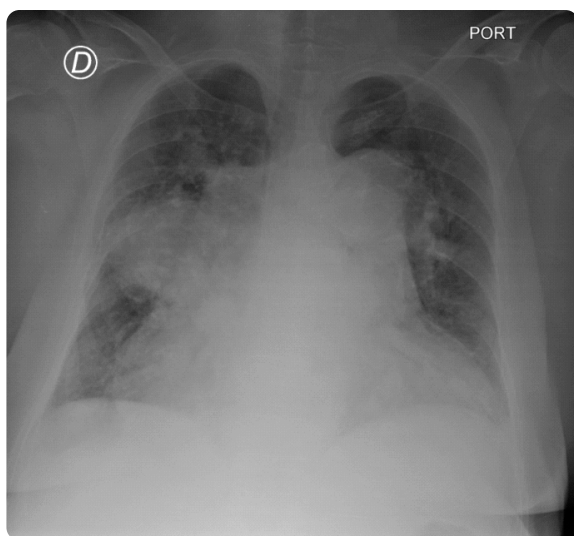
Portable chest X-ray in anteroposterior projection: widening of the vascular pedicle, prominence of the pulmonary hilae and global cardiomegaly. Additionally, a homogeneous rounded opacity is observed in the middle third of the right lung parenchyma with a diameter of 77 × 56 mm.
